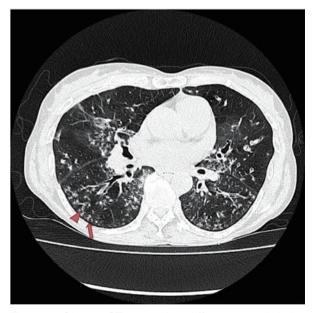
Chest CT reveals diffuse centrilobular nodules with branching opacities (tree-inbud pattern) (arrow), bronchiectasis, bronchiolectasis (arrow head) and mosaic attenuation of lung parenchyma.
